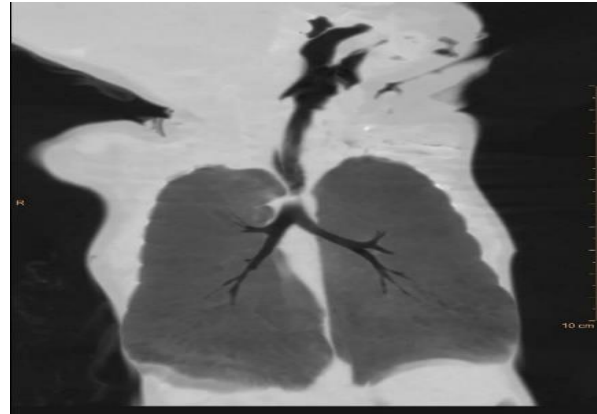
CT chest of compression of trachea.
